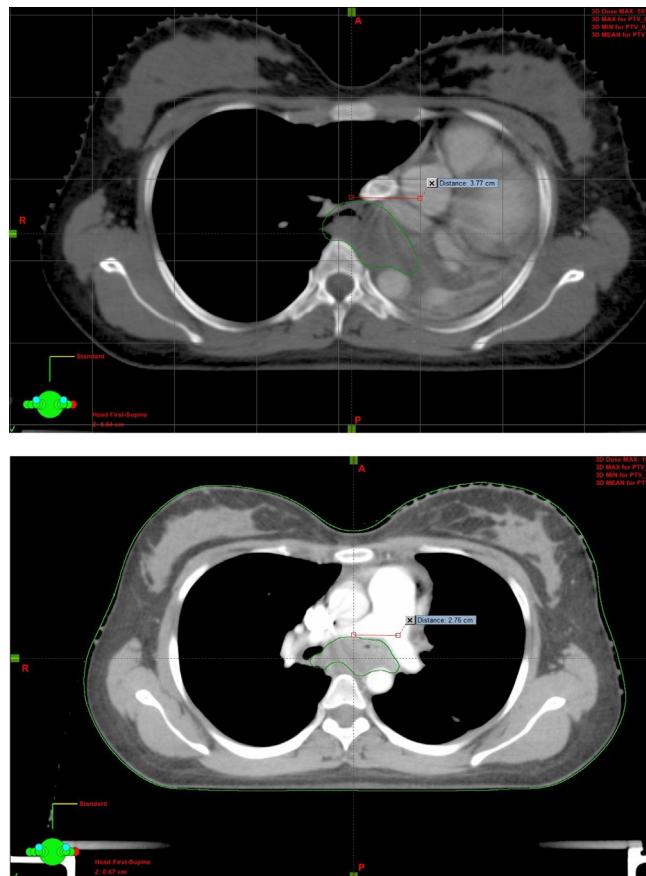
Axial section of CT scan showing shifting of GTV medially in comparison to pre treatment CT scan at corresponding level.
